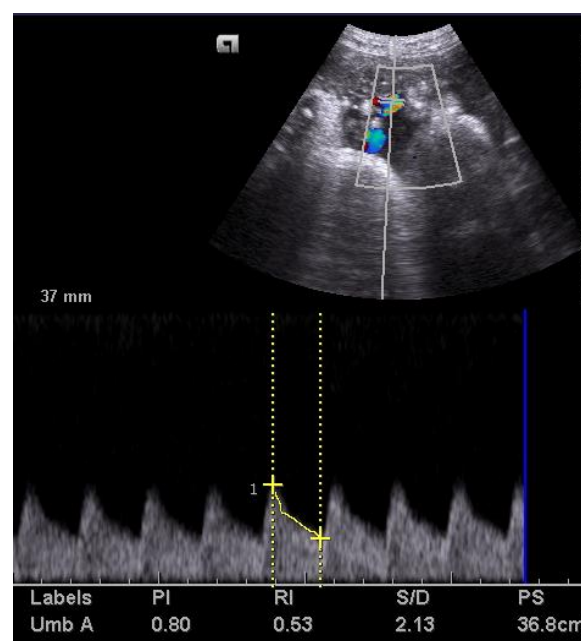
Normal Umbilical Artery Doppler
